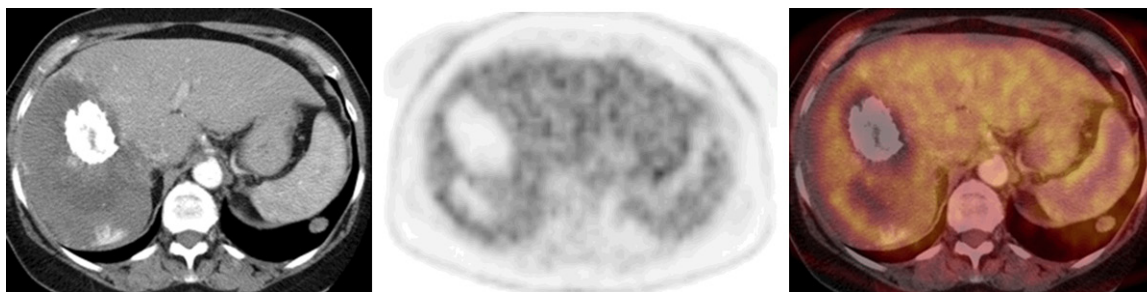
FDG PET/CT images in a case with giant hemangioma in the right lobe of the liver (selected transaxial CT, PET and PET/CT fusion images of the liver). CT shows calcification anteriorly, an area of lower attenuation posteriorly (scar, liquefaction or necrosis) and some contrast enhancement posterior to it. There is absent FDG uptake in the calcified and lower attenuation parts of the hemangioma and mild uptake in the rest of the hemangioma which is similar to normal liver activity.
